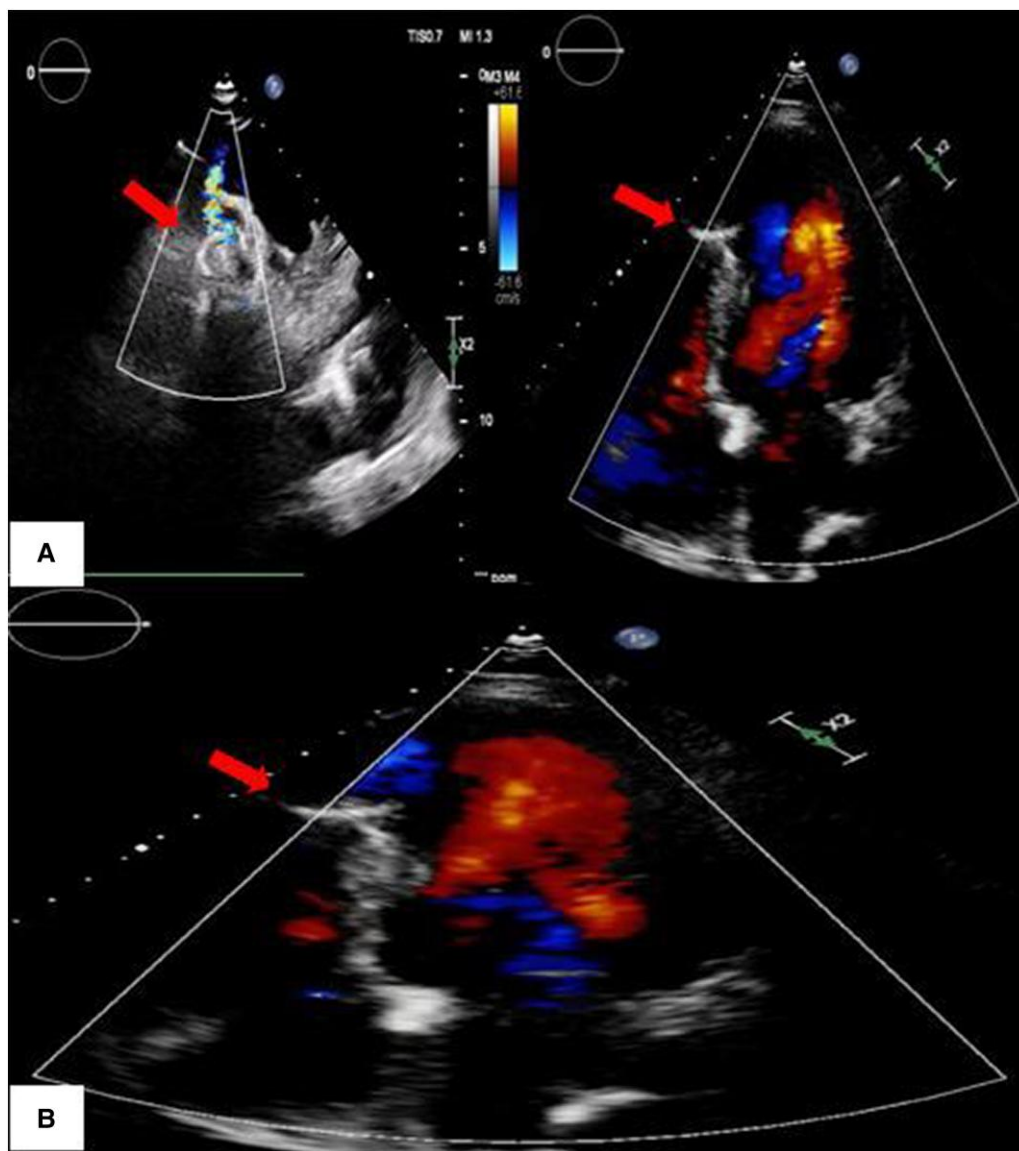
Immediate post-procedure, transthoracic echocardiography. (A) Patient 1, (B) Patient 2, four-chamber view demonstrating small residual shunt and patent ductus arteriosus occluder device positioned in the RV moderator band (arrow).
